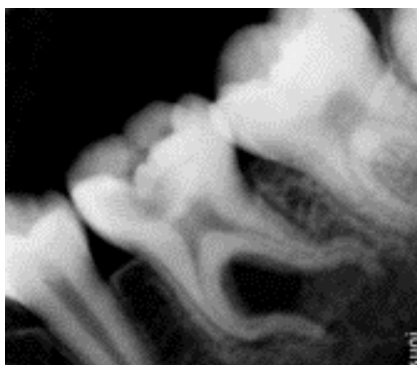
Preoperative radiograph of 36.
